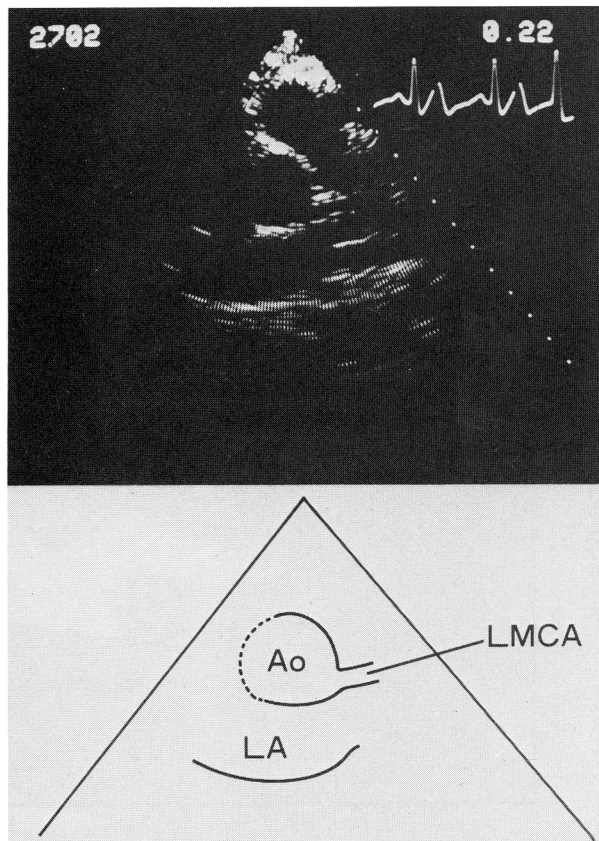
Cross-sectional echocardiogram of the normal left main coronary artery (LMCA) obtained from a patient with a fistula between the left coronary artery and the pulmonary trunk. The artery appears as two parallel dominant linear echoes that seem to arise from the inferolateral portion of the aorta (Ao) and to extend in a slightly anterior and leftward direction. LA = left atrium.
